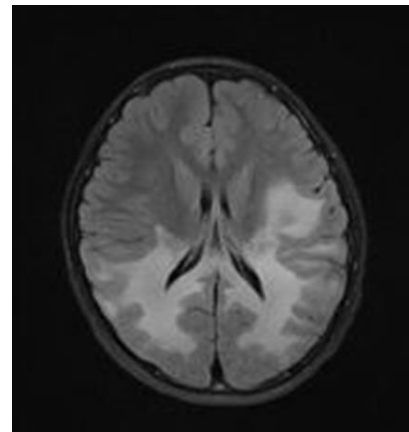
Bilateral cortical hyperintensities in DWI sequence in a patient diagnosed with hypoglycemic encephalopathy.
